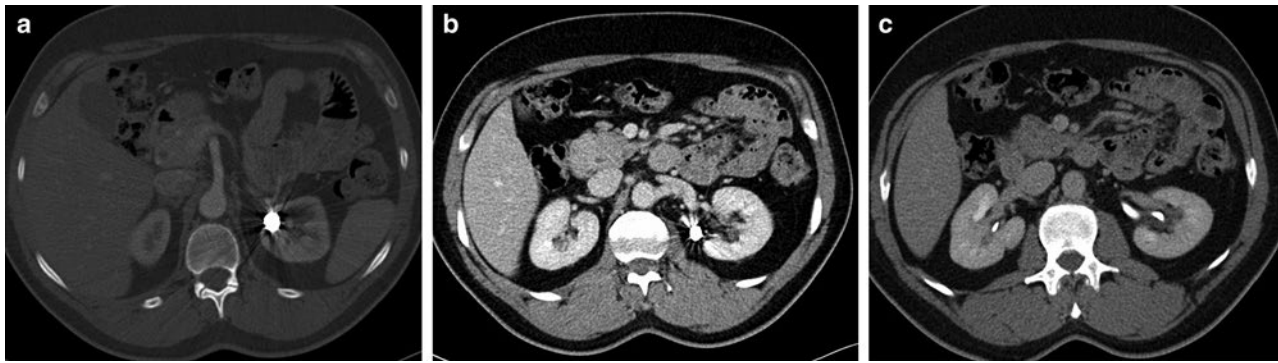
(a–c) CTA post-embolization confirms the complete exclusion of AV fistula and aneurysm with complete renal perfusion.
